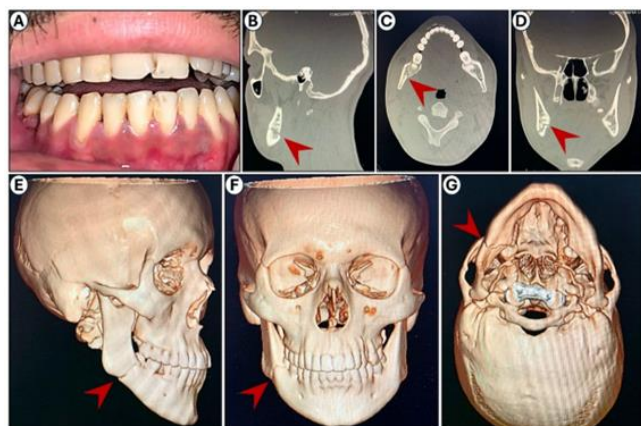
Preoperative clinical and tomographic evaluation. (A) Anterior open bite, demonstrating malocclusion associated with a right mandibular angle fracture. (B–D) Computed tomography (CT) images in sagittal, axial, and coronal planes, respectively. (E–G) Three-dimensional CT reconstruction. The red arrow indicates the right mandibular angle fracture (Source: Author).
